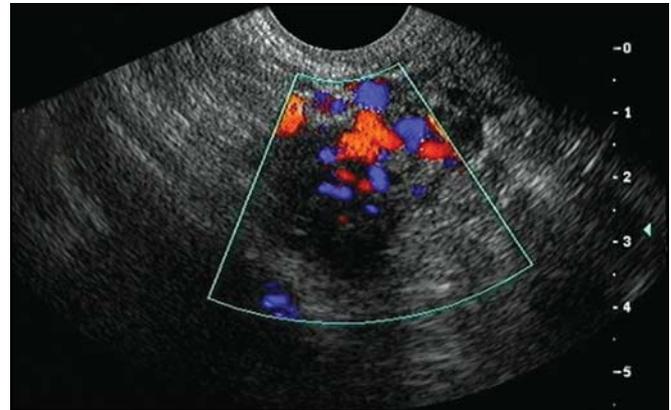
Highly vascular ovary visualized by color Doppler
